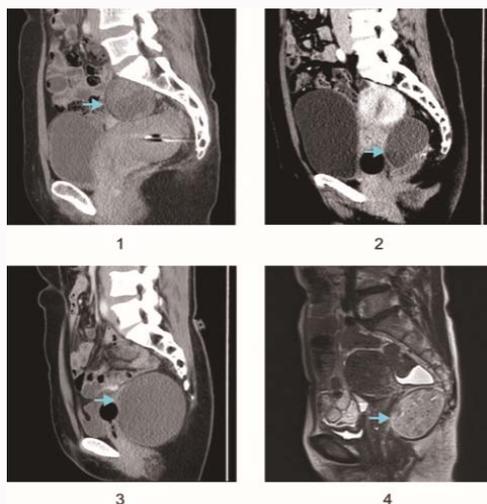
Sagittal images of benign presacral tumors on CT/MRI. The tumors are marked by the blue arrows.
